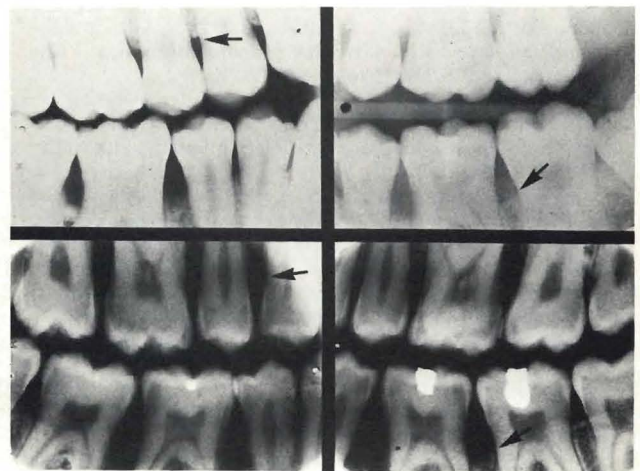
Bitewing radiographs of brother G.T. Top pair: 5-6-81; Bottom pair: 6-20-83. Note the progress of the disease (arrows indicate areas for comparison).
